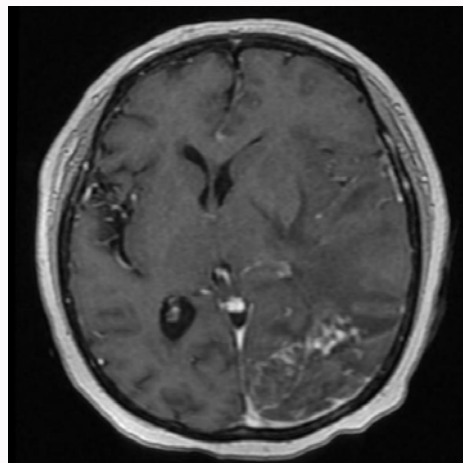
Brain MRI with contrast. Showed in the occipital region of the left side and ipsilateral wedge a ring enhancement after the intravenous contrast observing vasogenic edema which clears the parietal-occipital sulcus ipsilateral with maximum axis of 45 millimeters.
